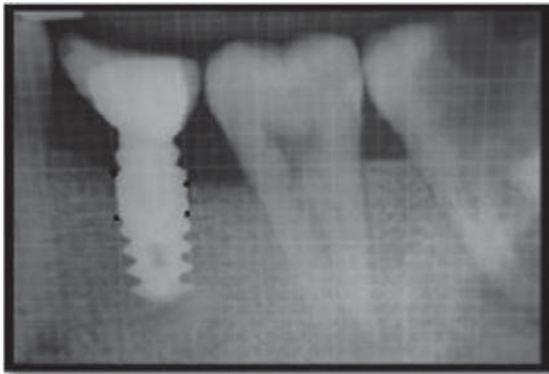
Grid used with iopa radiograph
